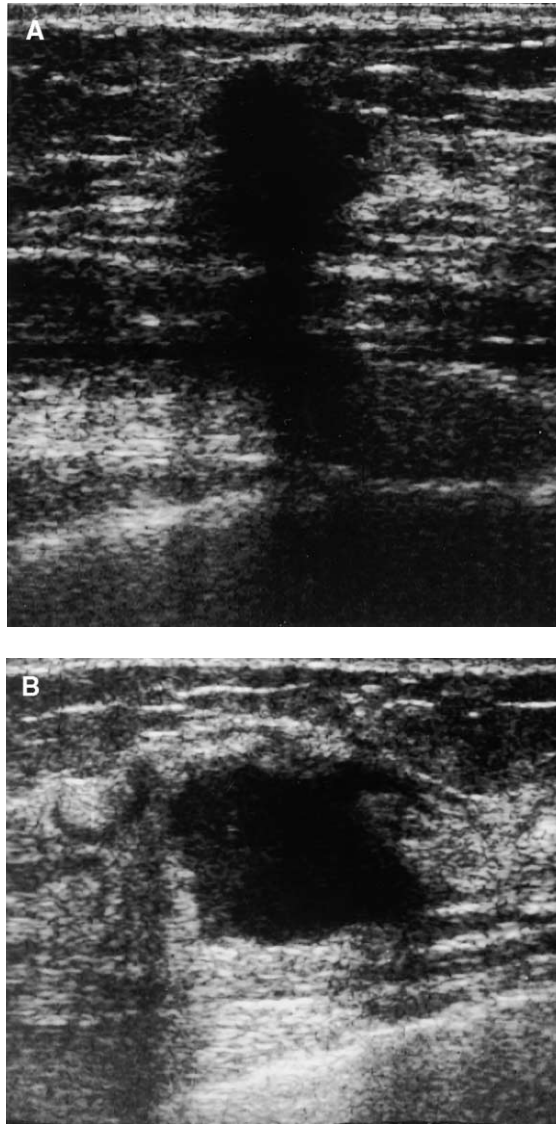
Sonographic findings in breast cancers. (A) Sonography shows a spiculated, irregular, hypoechoic mass that is taller than wide and has posterior acoustic shadowing. Biopsy showed infiltrating ductal carcinoma and ductal carcinoma in situ (DCIS). (B) Sonography shows lobulated, hypoechoic solid mass with ductal extension. Posterior acoustic enhancement (a feature more common in benign lesions) is observed. Biopsy showed infiltrating ductal carcinoma and DCIS.
